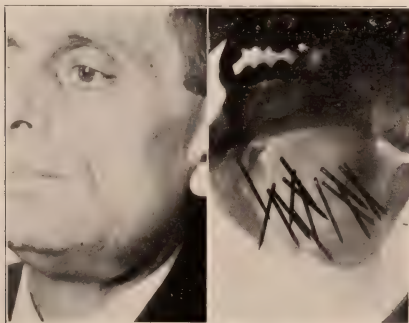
Swelling of the left lower jaw, with extensive destruction of bone. Heavy x-ray treatments over the outside, with one hundred and fifty milligrams of radium, in fifteen needles, imbedded into the cancerous tissue through the mouth, as shown in the radiograph. At the end of one month, several pieces of bones were removed from the inside. At the end of two months, odor practically stopped and patient gained considerable weight. Is steadily improving.
